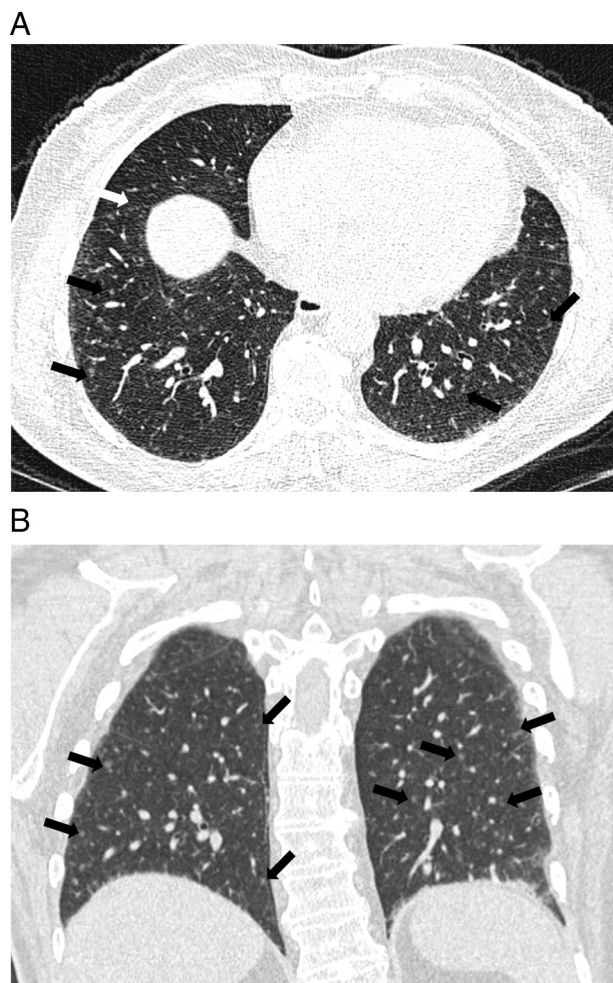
A–B. Lung window of axial (A) and coronal (B) high resolution chest CT images show multiple sub-solid (predominantly ground glass) lung nodules with a few representative examples indicated by arrows. These range in size from 2 to 4 mm and some are also seen along fissural surfaces (white arrow). Note the mild predilection for lower and peripheral lungs.
